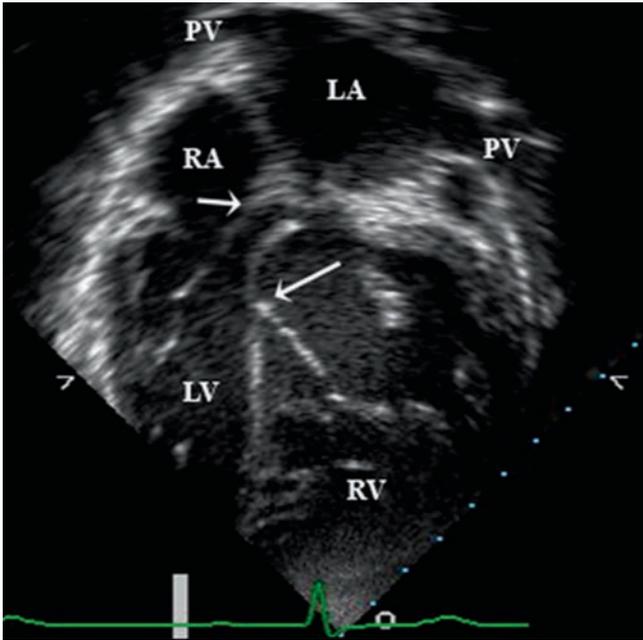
ccTGA Ebstein. Apical 4-chamber view in a patient with congenitally corrected transposition of the great arteries (atrio-ventricular; ventricular arterial discordance). The tricuspid valve has an Ebstein's like pathology with abnormal apical displacement (*long arrow*). The mitral valve attachment is shown by the *short arrow*. PV pulmonary vein; RA right atrium; LA left atrium; RV right ventricle; LV left ventricle
